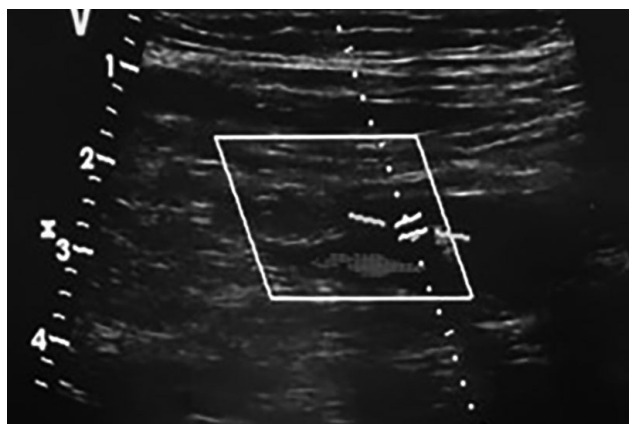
Vascular Doppler imaging reveals no vascular lesions adjacent to the hematoma.
